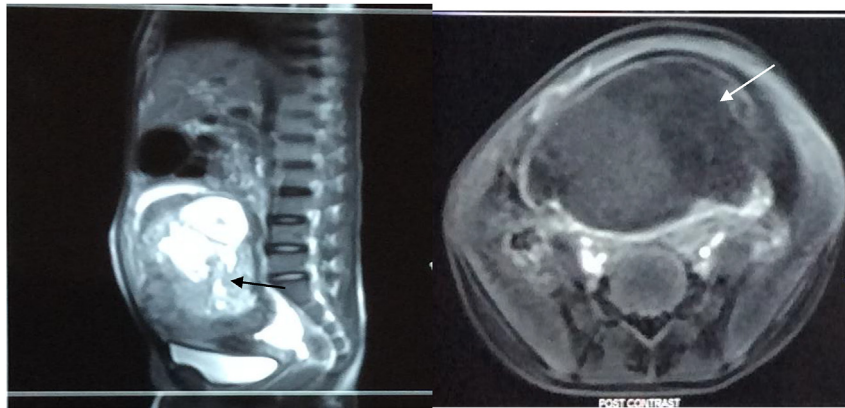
MRI abdominopelvic showing the mass of pelvic origin with both cystic and solid components (black arrow on the left and white arrow on the right).
